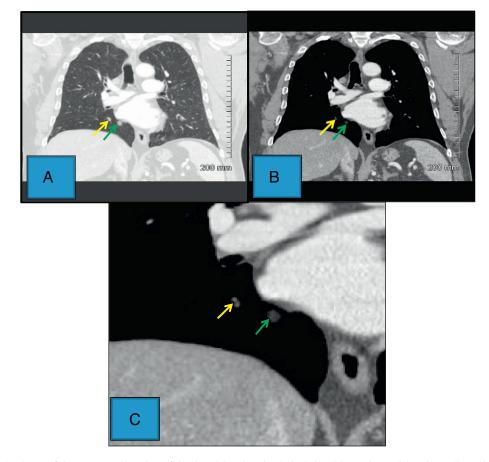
Coronal reconstruction image of the contrast-enhanced CT of the chest (A) and mediastinal window (B) reveals 2 nodules; the smaller nodule (yellow arrow) is solid, corresponding to adenocarcinoma, and the second larger nodule (green arrow) shows fat attenuation, corresponding to lipoma. C, A higher magnification view better demonstrates the fatty attenuation of the larger nodule (lipoma).
